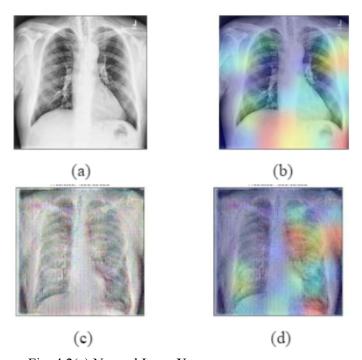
(a) Normal Lung X-ray
